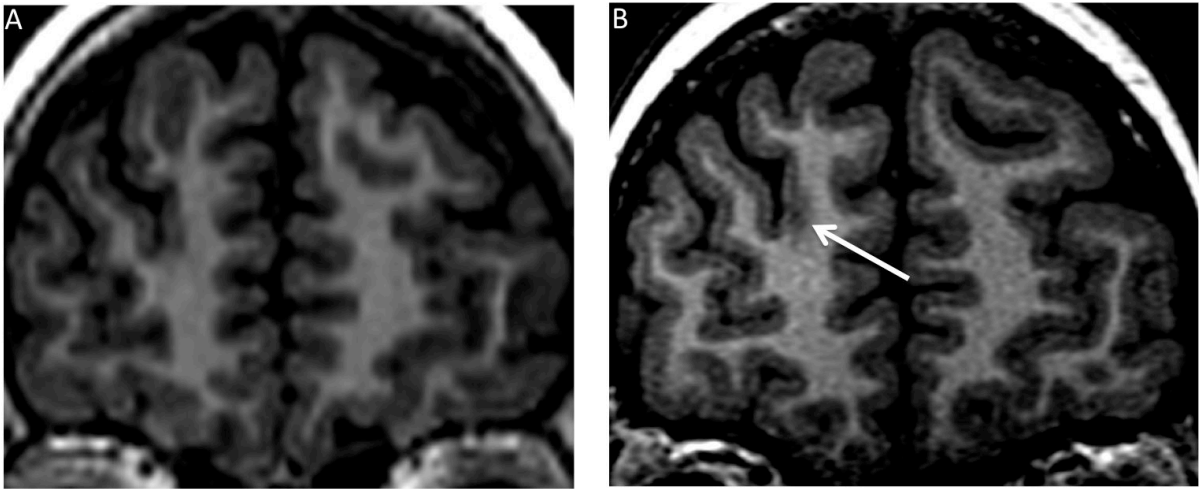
Other patient with FCD2 visible at 3T and overlooked at 1.5T: axial FLAIR images at 1.5T (A) and at 3T (B). Subcortical hyper intensity with a transmantle sign (arrow) is seen at 3T but not at 1.5T.
